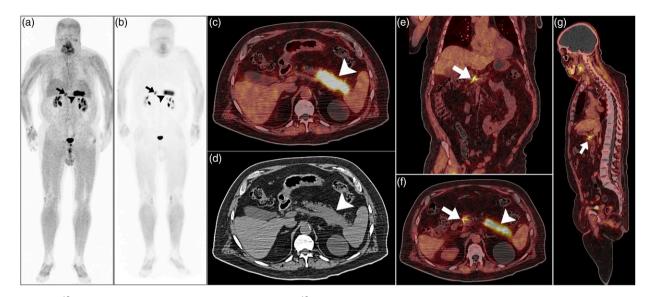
⁶⁸Gallium-Fibroblast activation protein inhibitor (⁶⁸Ga-FAPI) positron emission tomography/computed tomography (PET/ CT) was offered for a 77-year-old man to evaluate suspected pancreatic malignancy 10 days following recent gastroduodenal artery embolization. (a) Attenuation correction maximum intensity projection (MIP); (b) non-attenuation correction MIP; (c) axial PET/CT; (d) axial CT; and (e)–(g) coronal, axial, and sagittal PET/CT views exposed two foci of increased ⁶⁸Ga-FAPI uptake (annotations). (a–d, f) Images exposed an intensely ⁶⁸Ga-FAPI-avid pancreatic body and tail mass measuring about 7 cm in maximum dimensions (arrowheads). (a, b, e–g) Evidence of ⁶⁸Ga-FAPI expression surrounding metal coil artifact was observed correlating with the recent gastroduodenal arterial embolization (arrows).
